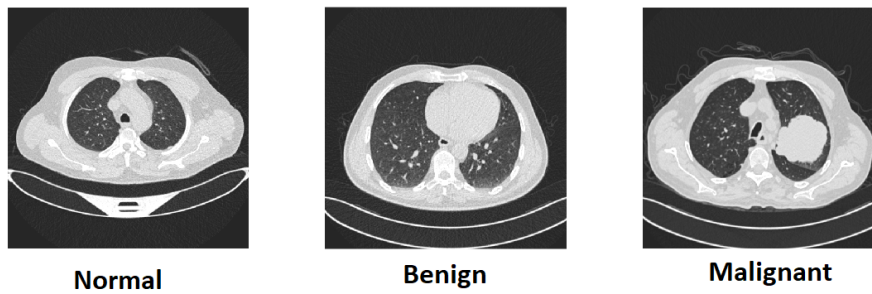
CT scan images of lung tumors of three classes
